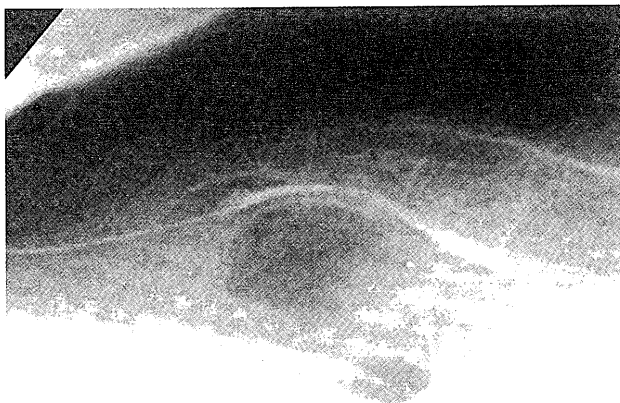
Lateral radiograph reveals correct placement of a bent needle (22-gauge, 7 cm) and the spread of the contrast medium for block of the ganglion impar.
